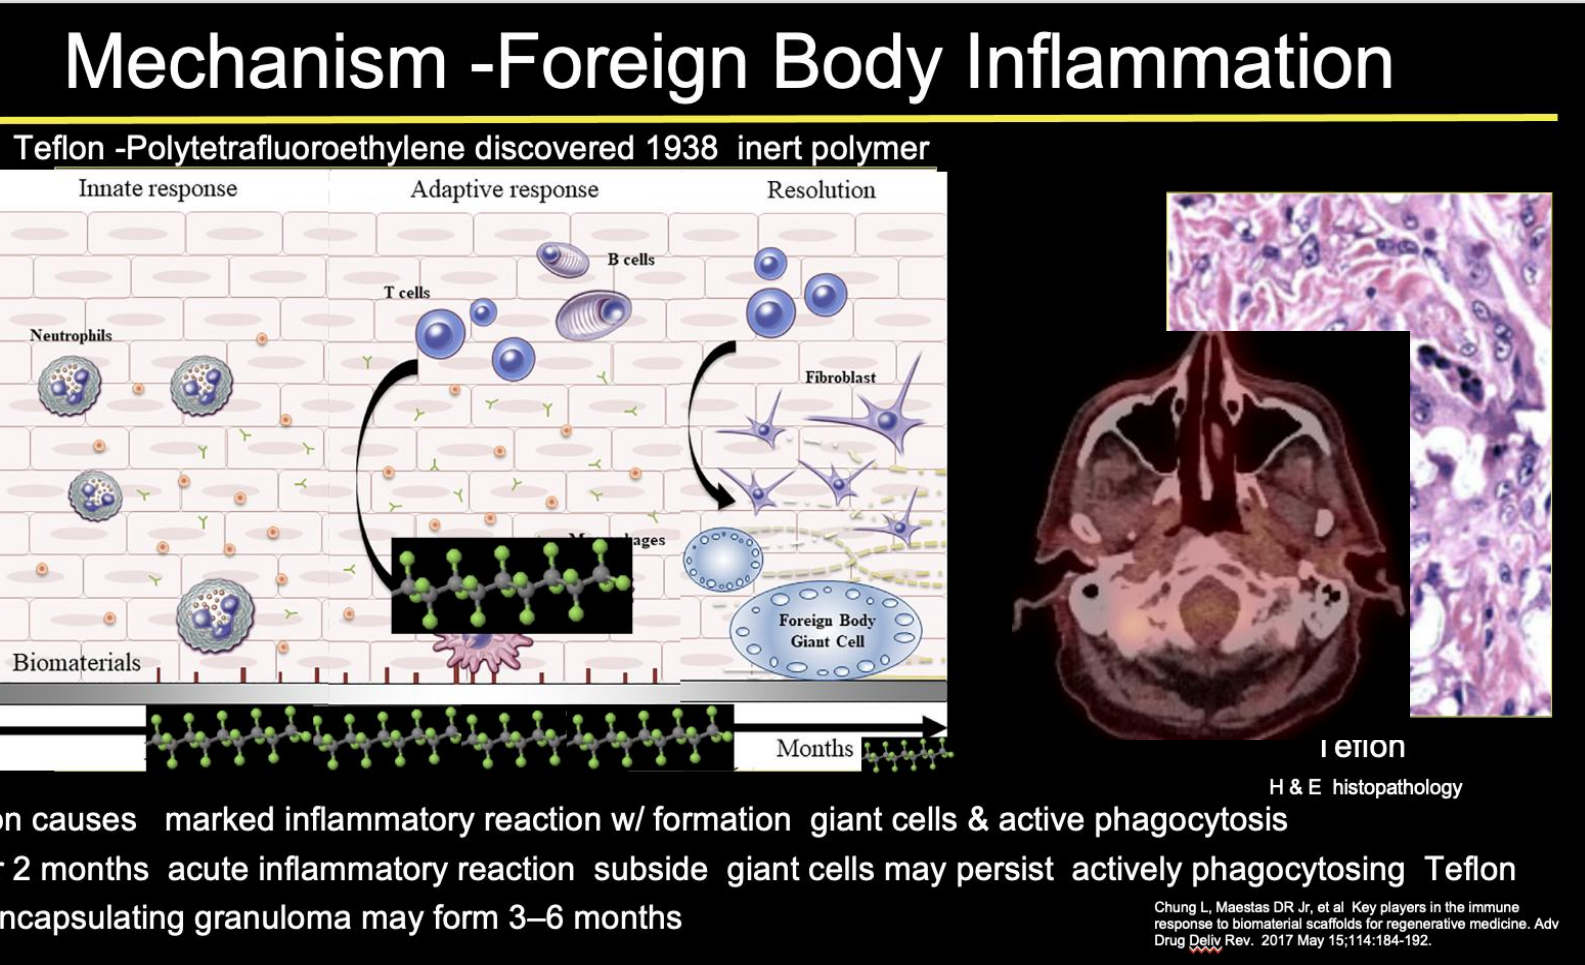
Teflon inflammatory response B, Coronal PET avid skull base mass, Axial CT high density Teflon material in the parapharyngeal space, axial T1 MRI axial T1 post-gadolinium MRI, with Teflon, surrounding enhancement. Patient had Teflon placed for treat patulous eustachian tube, 20 years prior. Teflon inflammation is a cause of false positive PET, knowing history of foreign materials is critical to avoid misinterpretation and false positives!
